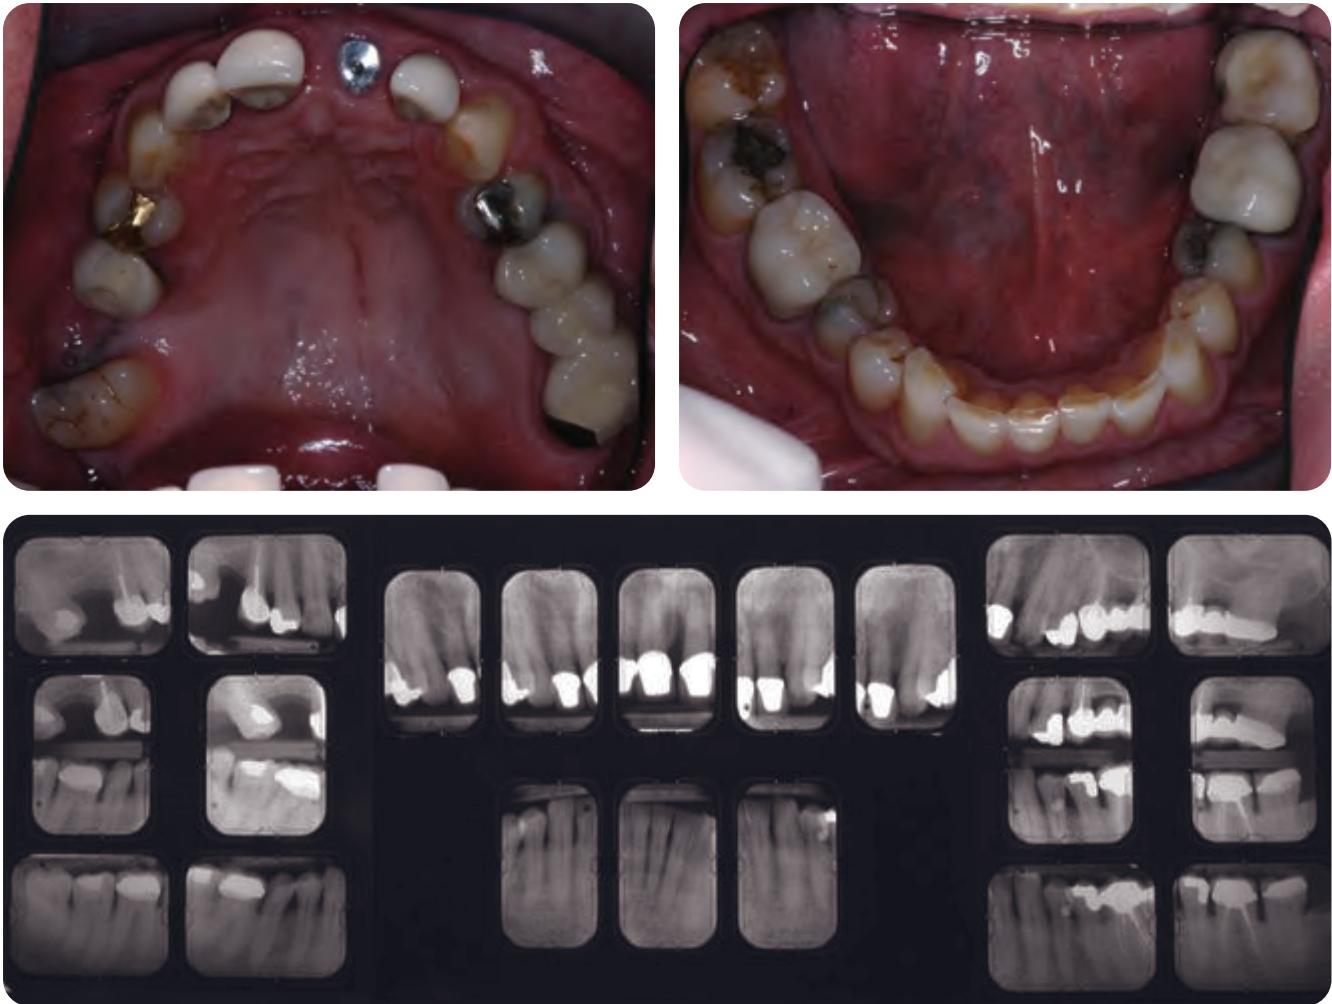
Pretreatment occlusal photographs and initial radiographs supplied by the treating periodontist. Posterior teeth need attention but will be phased appropriately for patient circumstances. Initial restorations will include maxillary first bicuspid to first bicuspid.
